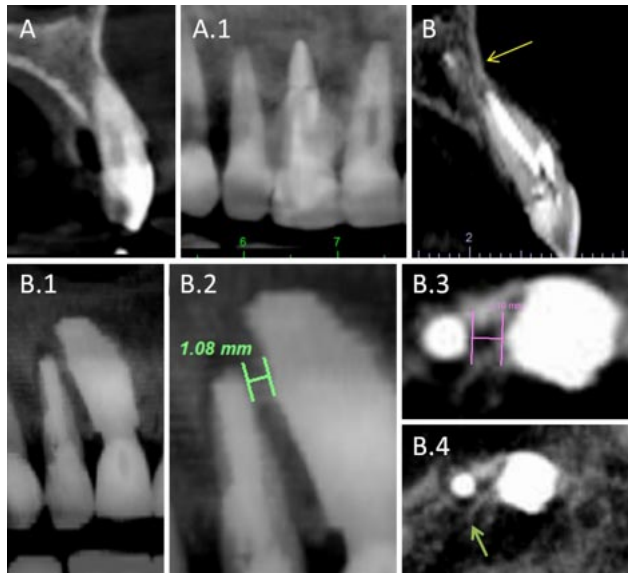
Case two: (A and A.1) before the implant placement surgery of tooth 11, the periapical region of tooth 12 had no injury. (B) the apical region of implant 11 (yellow arrow) below the apical region of tooth 12. (B.2) a panoramic cut demonstrates the proximity of the apical region of implant 11 with tooth 12, with a distance of 1.08 mm between the regions. (B.3) Axial section demonstrates the proximity relationship, and (B.4, green arrow) the apical lesion on tooth 12.
